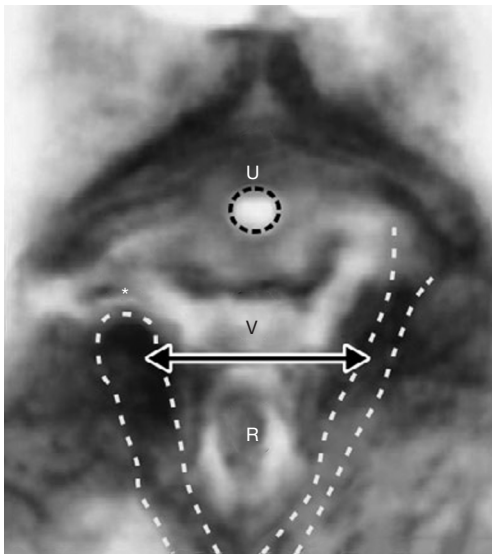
4D ultrasound of levator hiatus avulsion. View from above of the levator hiatus (arrows). Asterisk denotes a right-sided avulsion of pubococcygeus and/or puborectalis from its bony insertion point as a consequence of overdistension (see *Figure 7*). The pelvic muscles are outlined by broken lines. Reused from (1). With permission from Peter Petros; retains ownership of the copyright. U, urethra; V, vagina; R, rectum.
